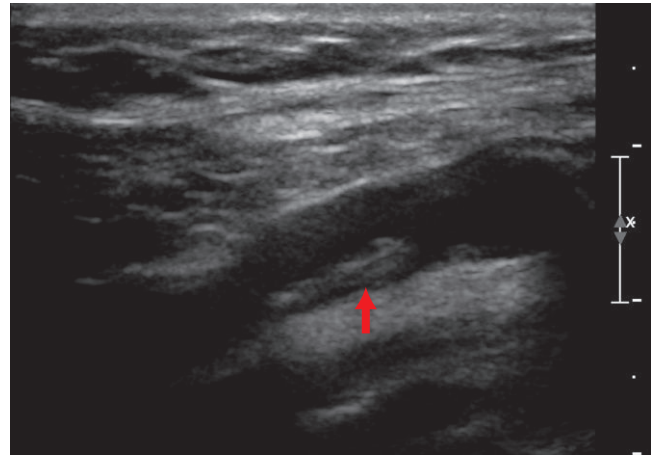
Gray scale ultrasound of the left internal carotid artery demonstrates plaque narrowing the lumen (arrow). The color Doppler in Figure S28-3 may underestimate the amount of plaque because the color can overwrite the lumen or, since plaque is eccentric, the scan can be over a less involved section of the vessel. Estimates of the amount of plaque should be made with gray scale, not color Doppler.
